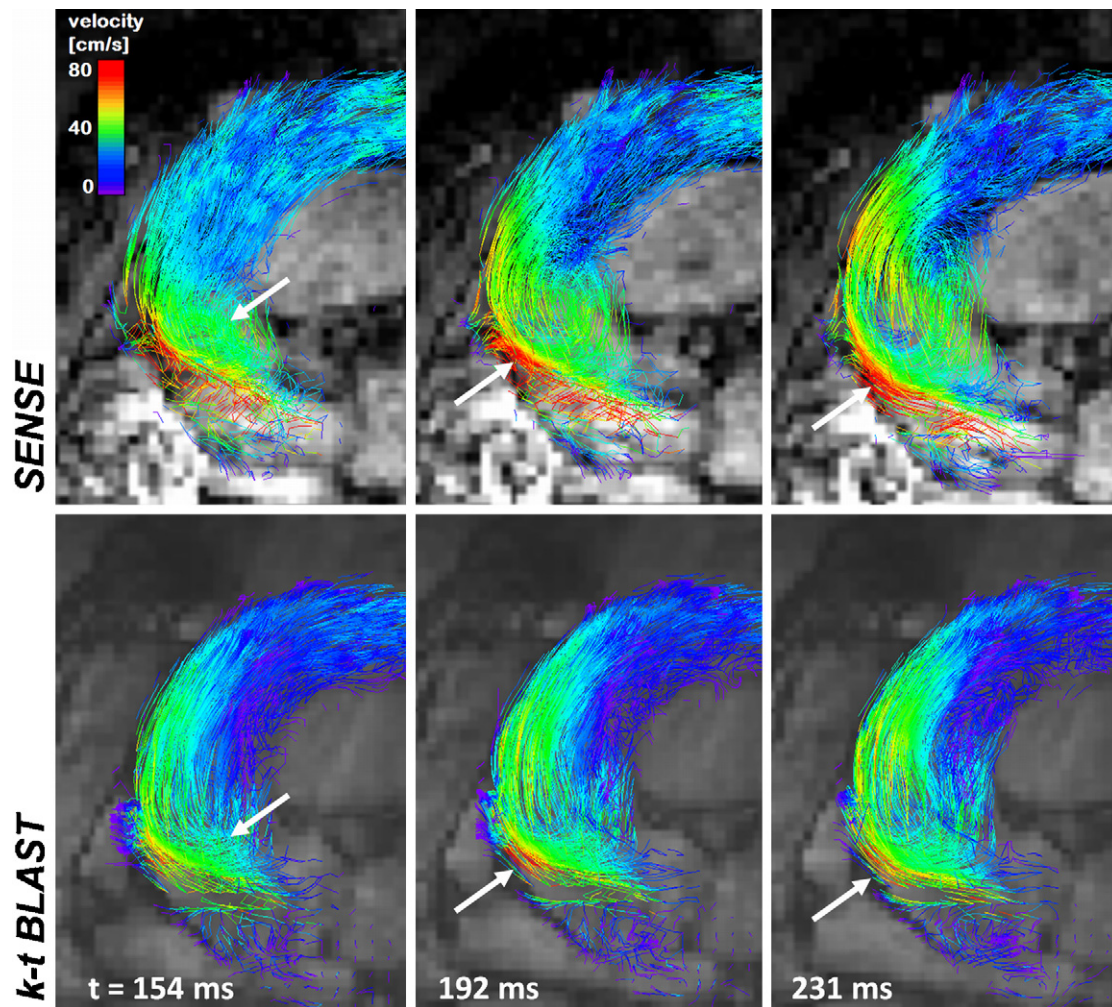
Temporal evolution of blood flow in the aorta of a 73-year-old female patient with an ectasia of the ascending aorta: 3D streamlines for three successive early systolic time frames measured with PC-MRI in combination with SENSE ($R=2$) (upper row) and k-t BLAST 6 (lower row). The color code is overlaid in the upper left image. The white arrows point to the most distinct differences between the SENSE and the k-t BLAST experiment.
